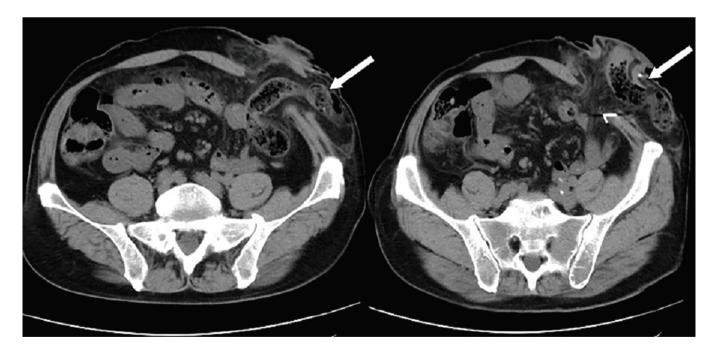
Periostomy hernia. Abdominal computed tomography indicated a visible intestinal canal protruding into the subcutaneous fat layer (arrows).
